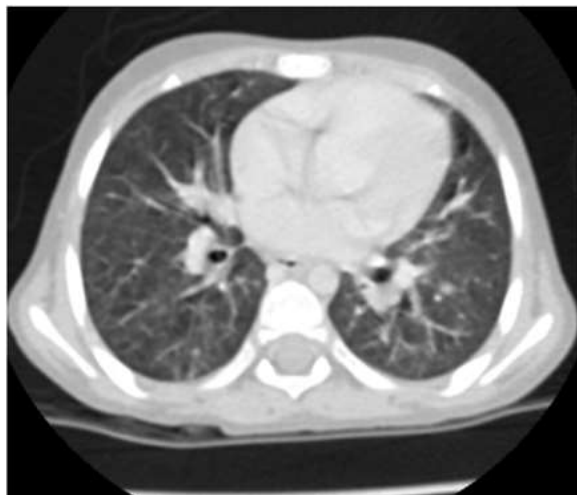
CT Chest showing good resolution of cavitary lesions.
